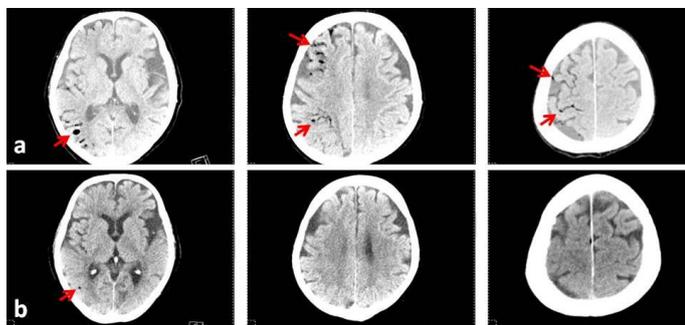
/b. Pneumocephalus areas on CT images before/after hyperbaric oxygen therapy
